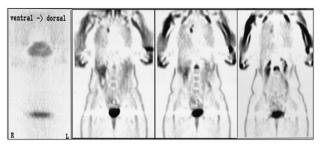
Full body positron emission tomography with F18 - FDG preoperatively at a 46-year-old female patient with suspected metastases in the skeleton and other organs of an unknown tumor
